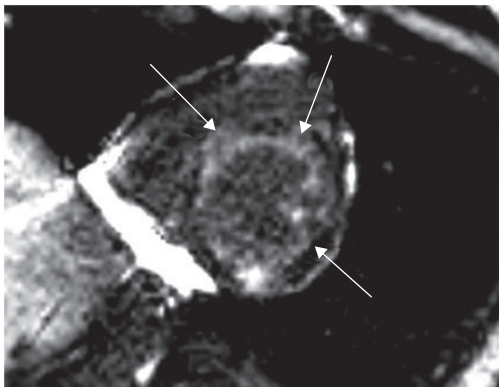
Short axis delayed enhancement MRI shows circumferential patchy subendocardial enhancement extending into the neighboring myocardium.
